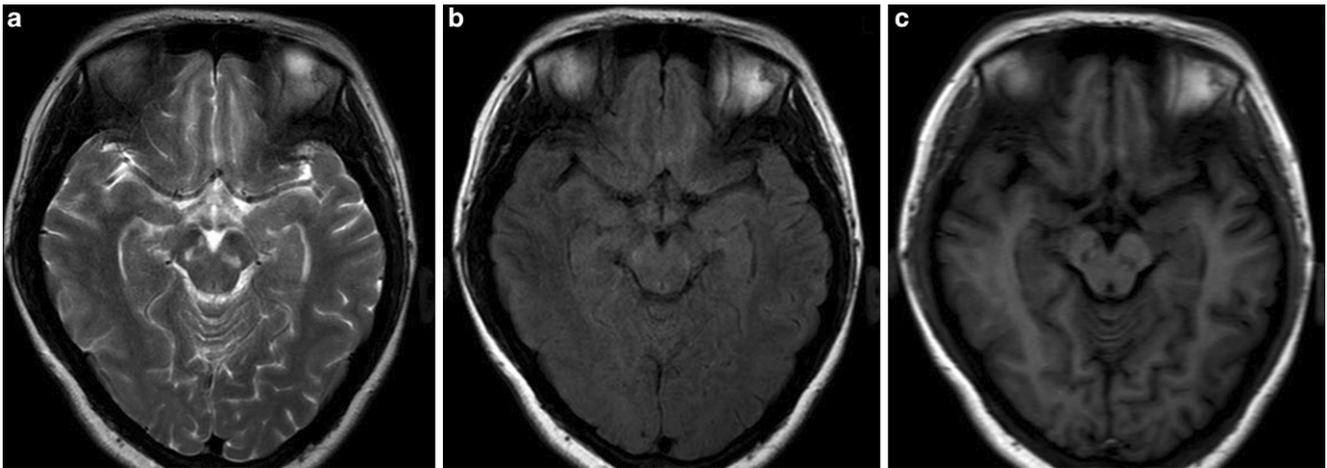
a After treatment with acyclovir and levodopa and benserazide hydrochloride tablets, the hyperintense lesions in the bilateral substantia nigra on T2-weighted imaging decreased with clearer boundaries. b The lesions in the fluid-attenuated inversion recovery sequences decreased but became blurry. c T1-weighted imaging showed that the lesions in the bilateral substantia nigra became smaller with clearer boundaries after treatment
